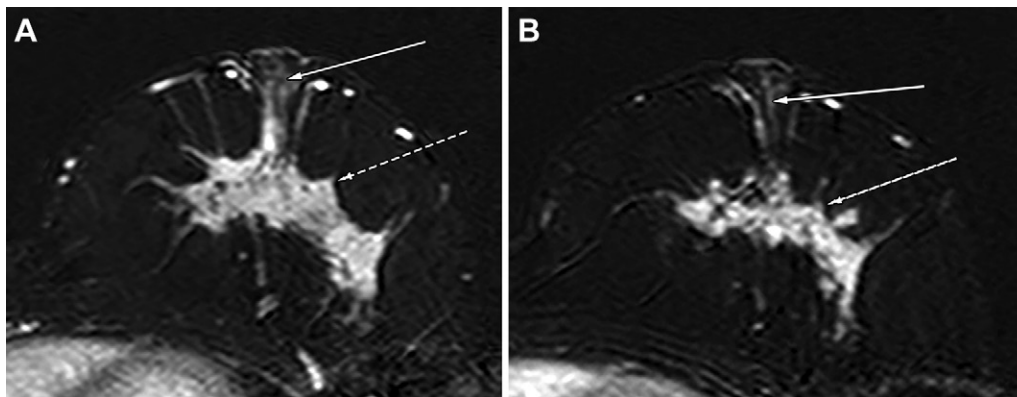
MRI scans in a 49-year-old woman with hormone receptor–positive and human epidermal growth factor receptor 2–negative breast cancer with nonmass enhancement (NME) extension to the nipple at MRI before and after neoadjuvant chemotherapy (NAC). The patient was administered four cycles of anthracycline and cyclophosphamide every 3 weeks, followed by 12 cycles of weekly paclitaxel. (A) Pre-NAC MRI scan shows a mass-like lesion (dashed arrow) with linear NME extending beyond the nipple base (solid arrow). (B) The mass-like lesion decreased slightly (dashed arrow), but NME extension to the nipple is still observed on the post-NAC MRI scan (solid arrow). The presence of tumor invasion of the nipple was confirmed with pathologic evaluation.
